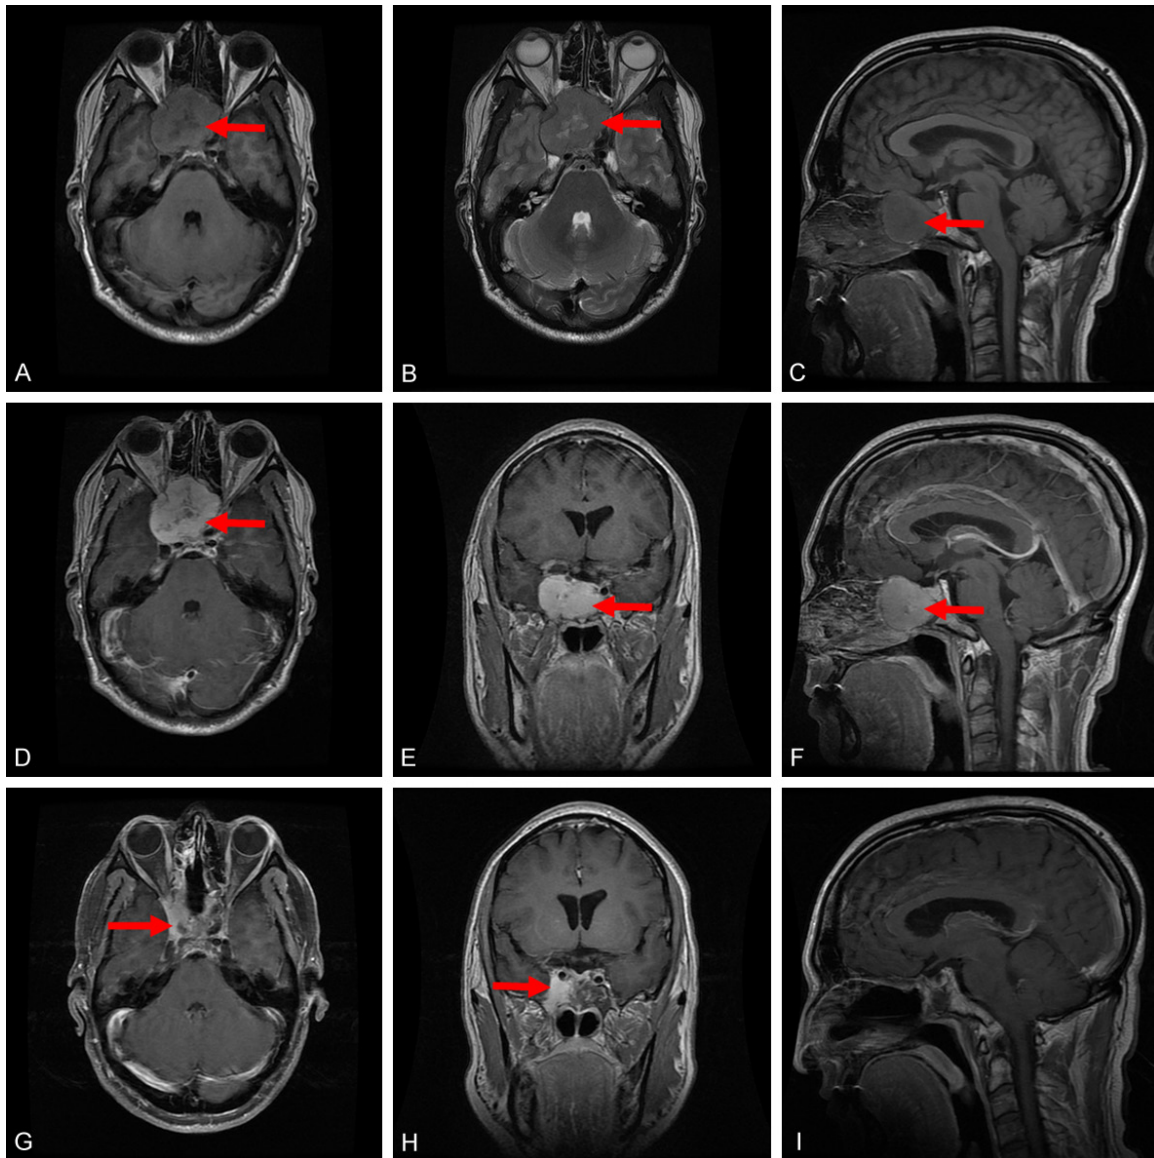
The pre-operative and post-operative MRI scans of the patient. (A, B, D: T1-/T2-weighted/ enhanced) Axial, (C, F: T1-weighted/enhanced) sagittal, and (E: Enhanced) coronal magnetic resonance images demonstrate an enhanced mass (red arrows) invading the cavernous sinus and involving the internal carotid artery and optic nerve, but the mass does not enter the cranium. (G) Axial, (H) Coronal, and (I) sagittal enhanced postoperative magnetic resonance images demonstrate a small residual tumor (red arrows) in the cavernous sinus.
